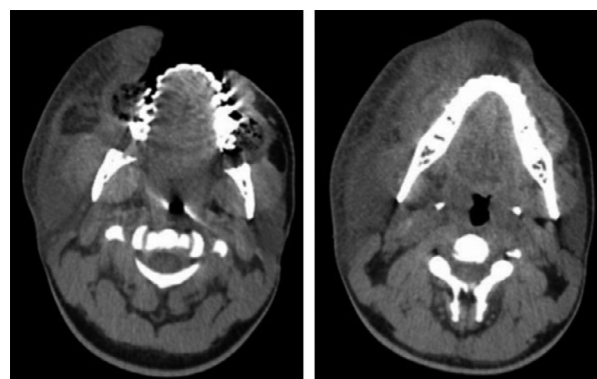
Axial views of the maxillofacial computed tomography (CT) scan without intravenous contrast obtained upon admission.
